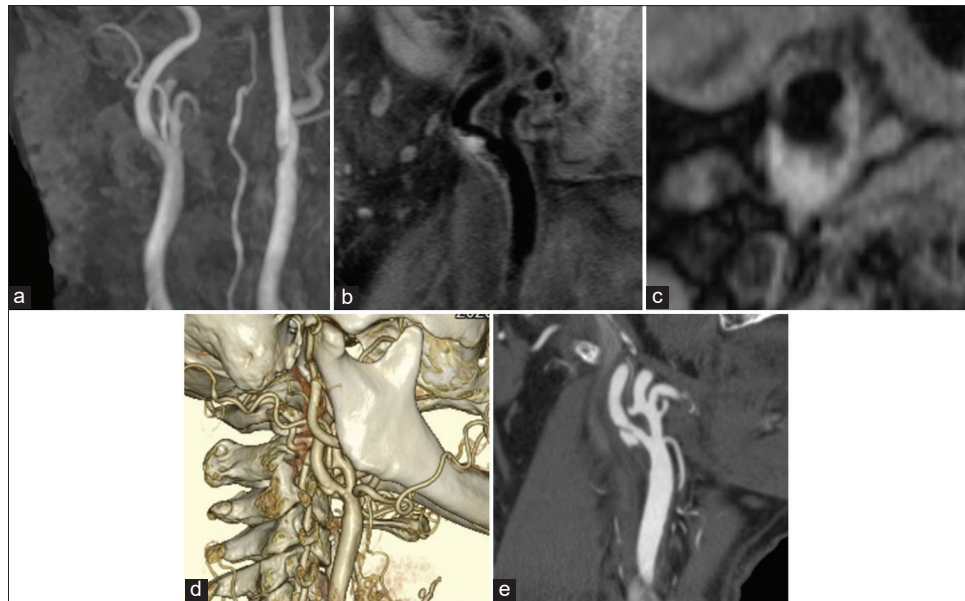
(a) Magnetic resonance (MR) angiography revealing mild stenosis with white plaque at the origin of the right internal carotid artery (ICA). (b and c) MR plaque imaging (T1-weighted fat suppression black blood) revealing a high-intense (b; sagittal, c; axial). (d) Three-dimensional computed tomographic angiography (CTA) revealing mild stenosis with ulcer formation at the origin of the ICA. (e) A sagittal CTA maximum intensity projection image demonstrating a carotid web lesion.
